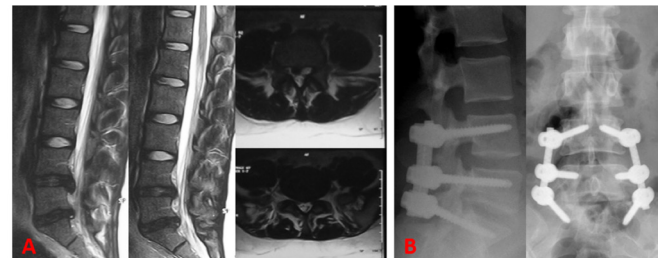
Forty-year-old male patient with back and right leg pain. Sagittal and axial section MRIs (A) are seen. A dream rod was used with dynamic screws. Antero-posterior and lateral radiographic views after the operation (B)
